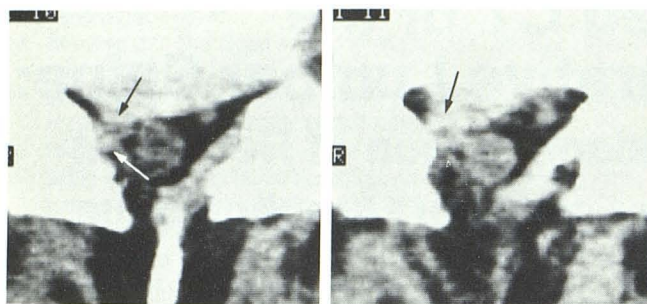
Scar resembling recurrent herniated disk: nonenhanced study. After right diskectomy at L5–S1, recurrent S1 radiculopathy developed. CT showed soft-tissue mass and right-sided bulge of annulus (black arrows). Right S1 root (white arrow) is displaced posteriorly. Thecal sac is not affected. CT findings strongly suggested recurrent herniation, and myelogram showed cutoff of S1 on right. At surgery a hypervascular scar was found, but no disk herniation. Right S1 root was entrapped by scar.
